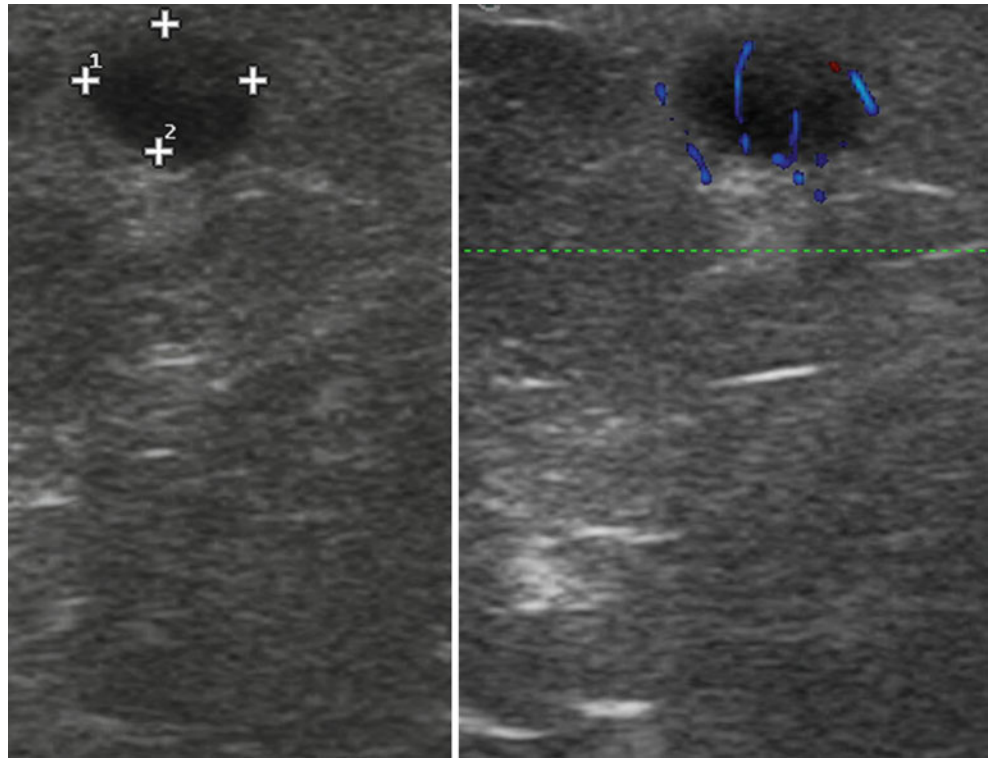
In-transit metastasis. Small (4 mm) melanoma nodule is visible within the inguinal region. Despite the very small size, flow signals are visible on the directional power Doppler image
